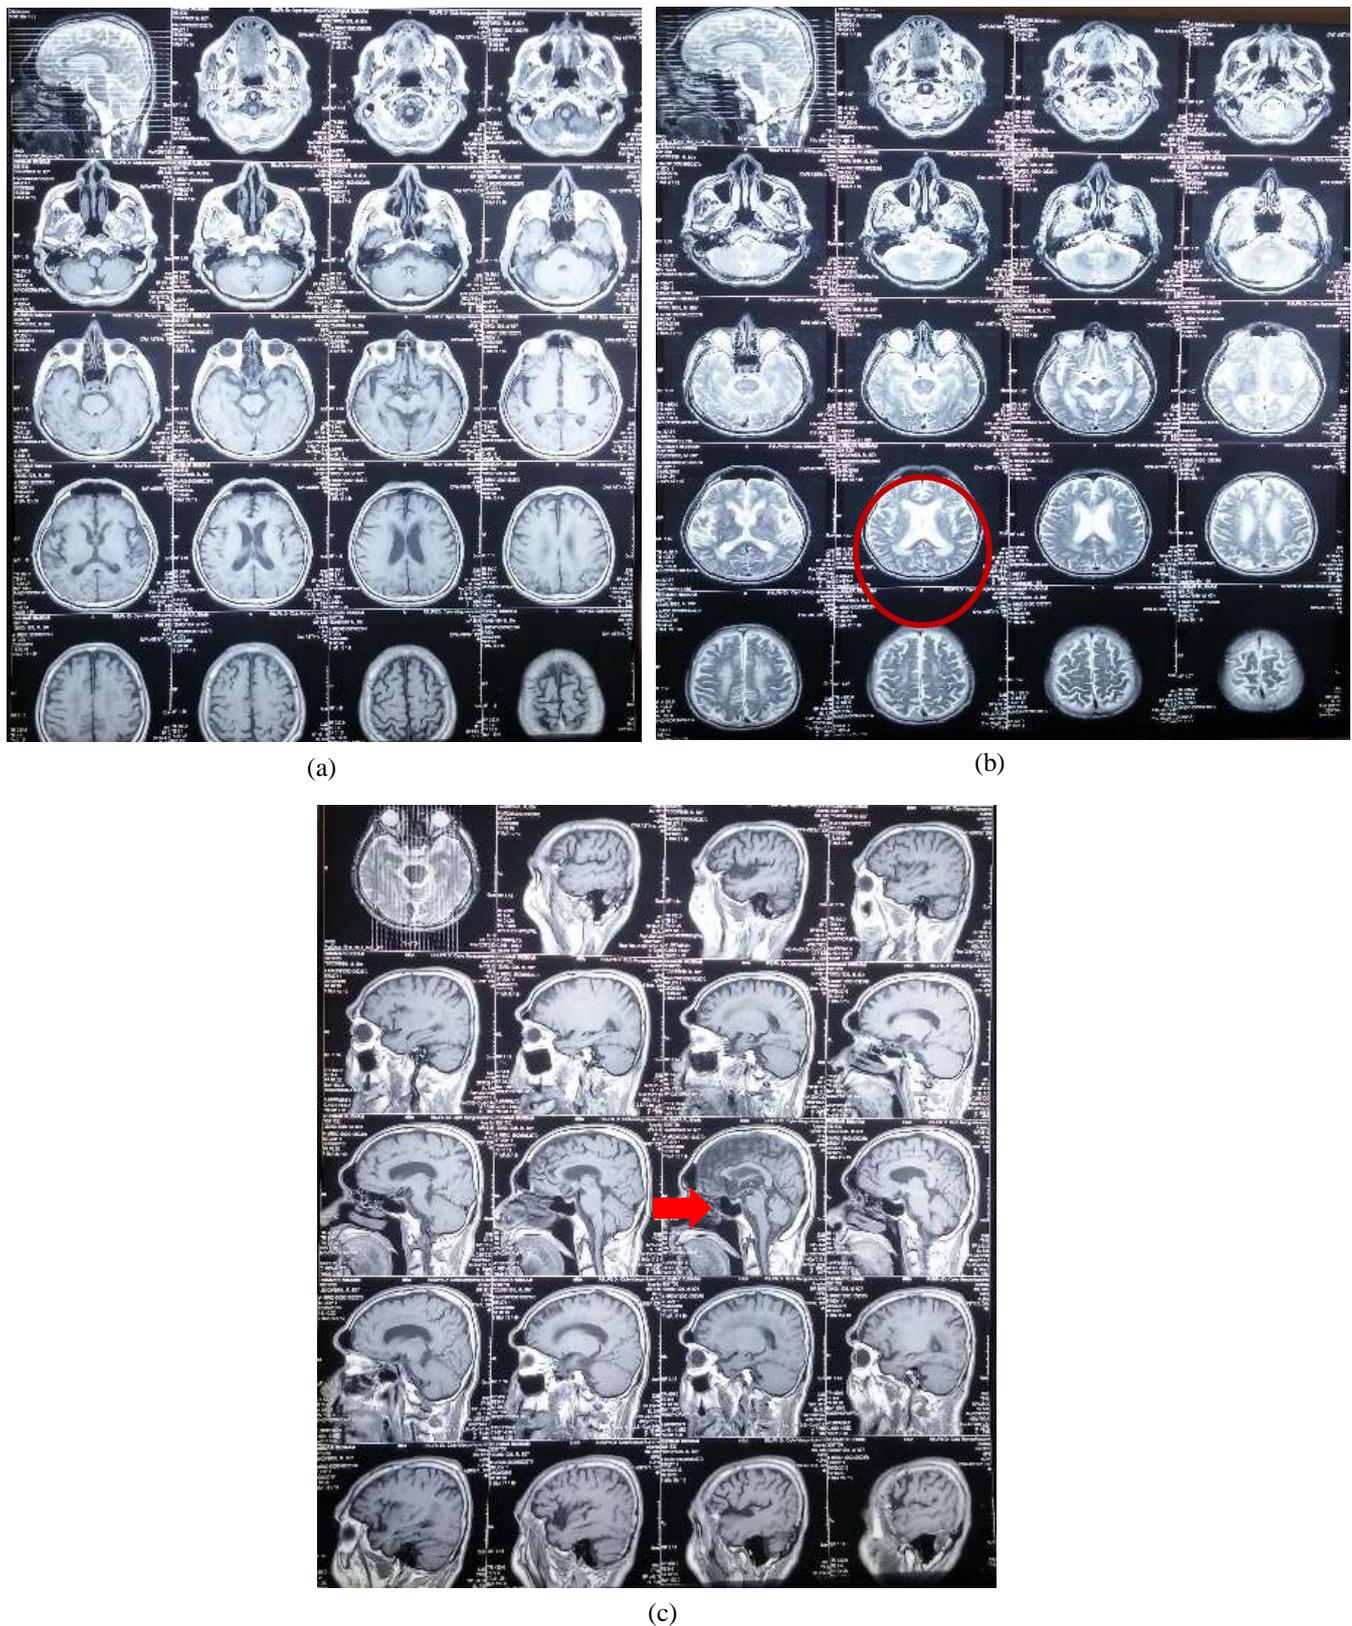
Non-contrast head MRI, a) T1WI axial slice, b) T2WI axial slice with bilateral periventricle white matter lesion (red circle), c) T1WI sagittal slice with hummingbird sign
